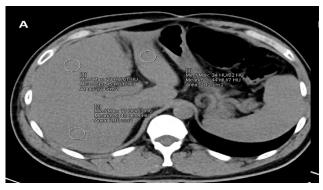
An unenhanced transverse CT image depicts a circular region of interest (ROI) measuring 1.5×1.5 cm (white circle), deliberately placed to avoid major blood vessels. The ROI is strategically positioned across the right anterior-posterior and left hepatic lobes.
